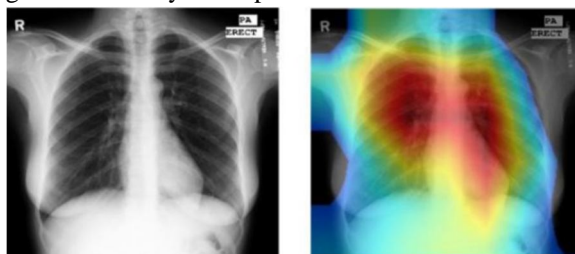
A test case using CAMs in the identification of normal X-Rays, with an emphasis on clear lung area.
